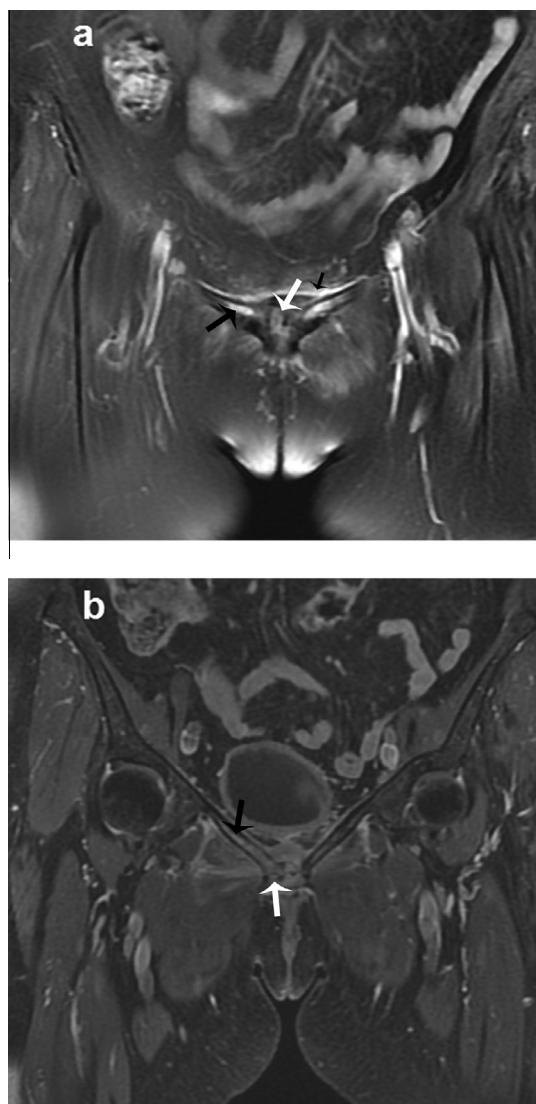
(a, b) Coronal T2-weighted image (TR/TE, 3360/82) with fat suppression (a) demonstrates the abnormal hyperintensity along the iliopubic rami, subchondral marrow (black arrow) and within the joint space (white arrow) with surrounding soft tissue edema (small black arrow). Coronal post-contrast T1-weighted image (TR/TE, 700/17.6) with fat suppression shows marrow enhancement of the iliopubic rami and subchondral bone of the symphysis pubis (black arrow). Note also the irregularity of the articular surfaces (white arrow).
